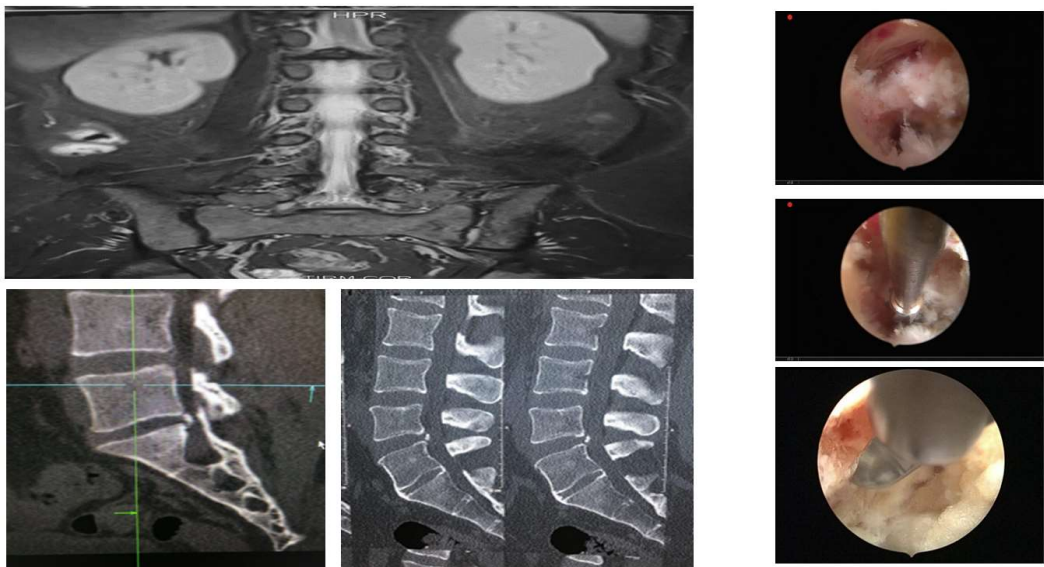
A B shows a left side undercut non-articular ventral facet for mid zone decompression. Rt. we see ventral facet undercut up to facet edge for central canal decompression in CT.
